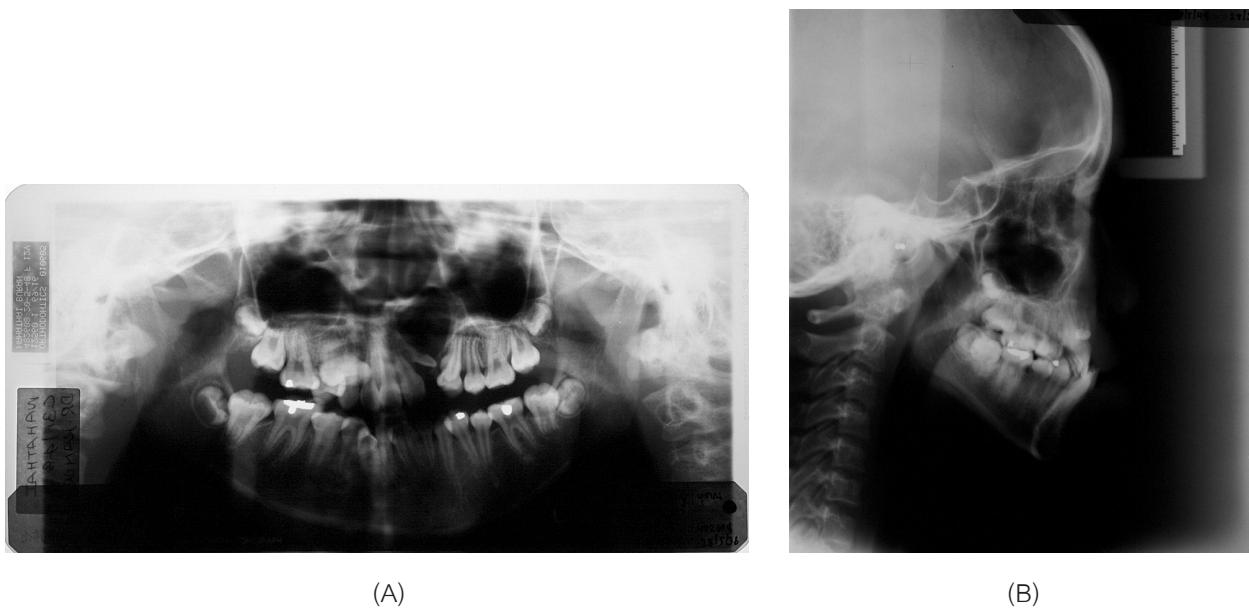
Panoramic radiograms (A) and lateral cephalograms (B) at pretreatment
